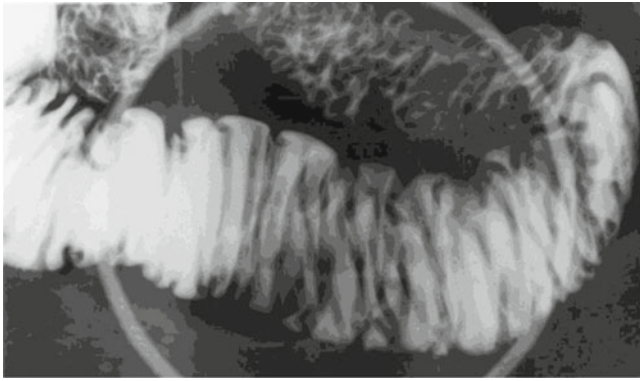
Radiography. Under compression, Kerckring's folds in the jejunum exhibited comparatively even, mild enlargement
